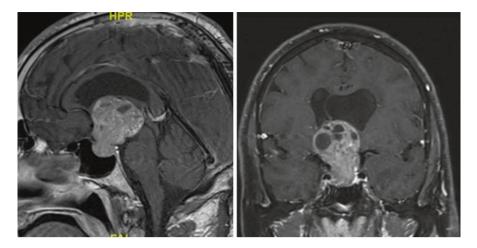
Pituitary adenoma: Sagittal and coronal T1-Gad MRI showing a giant nonfunctioning pituitary adenoma with obstructive hydrocephalus in a 55-year-old. The tumor was resected via a transcallosal approach
